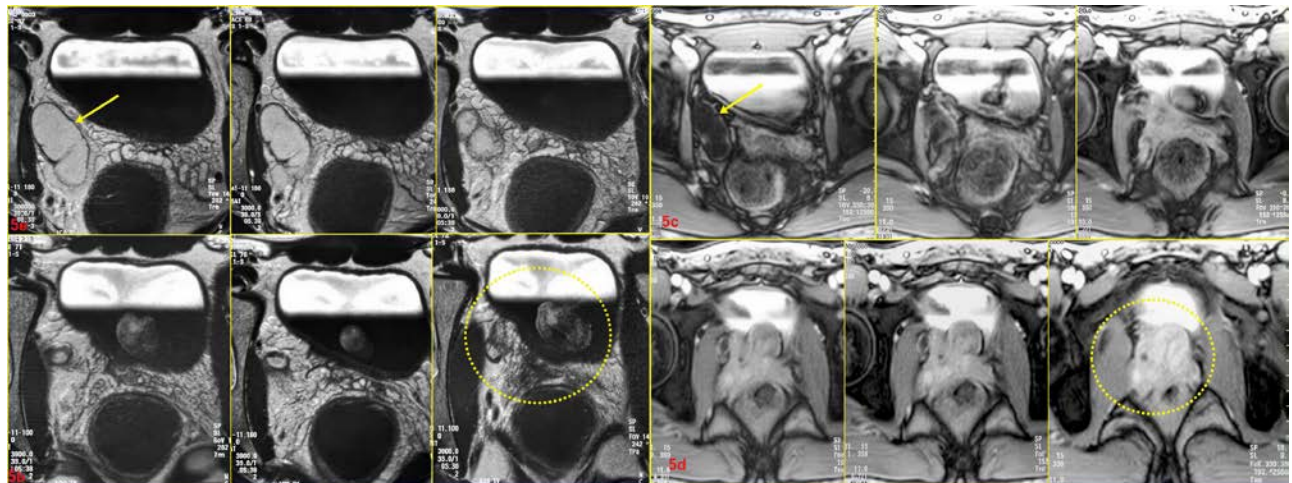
a-d Axial T2-weighted images which show (a) clearly the cystic mesonephric duct (Arrow) and (b) the abnormal metanephric blastema (Circle). Axial post contrast T1-weighted images which show clearly (c) the cystic mesonephric duct (Arrow) and (d) the abnormal metanephric blastema (Circle)
